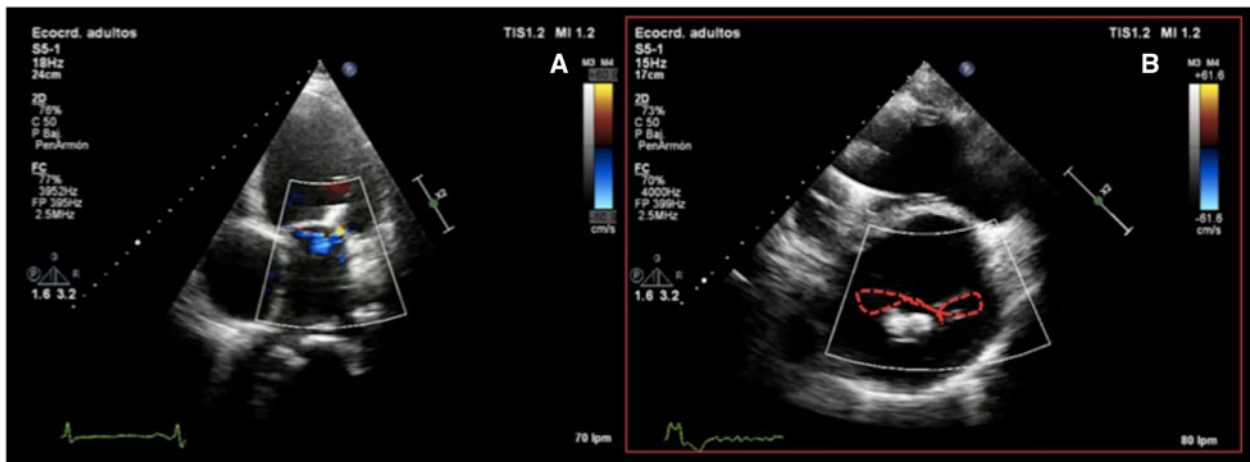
Apical four chamber view with Doppler colour showed mild mitral regurgitation jet (A). In sternal short axis of mitral valve, it is possible to appreciate a figure that resembles a bow tie with central clip (B).
